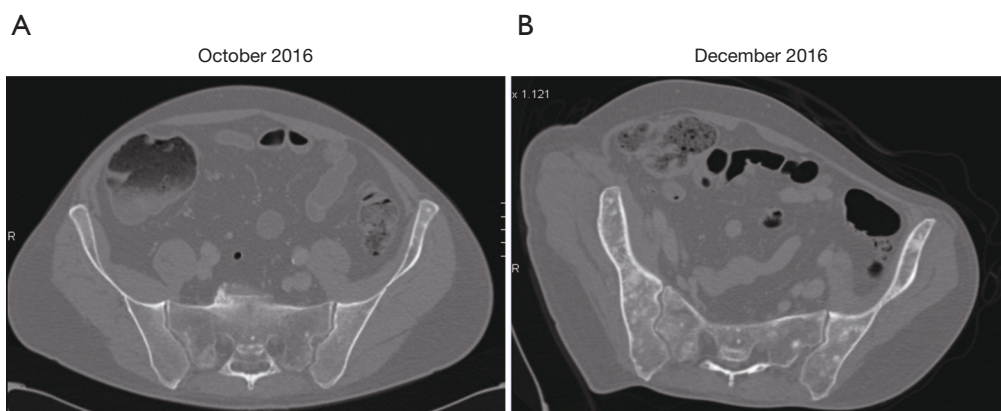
CT scans of new lesions observed upon ceritinib progression. (A) October 2016 CT scan with no evidence of PD; (B) December 2016 CT scan showed several new ischium lesions.
